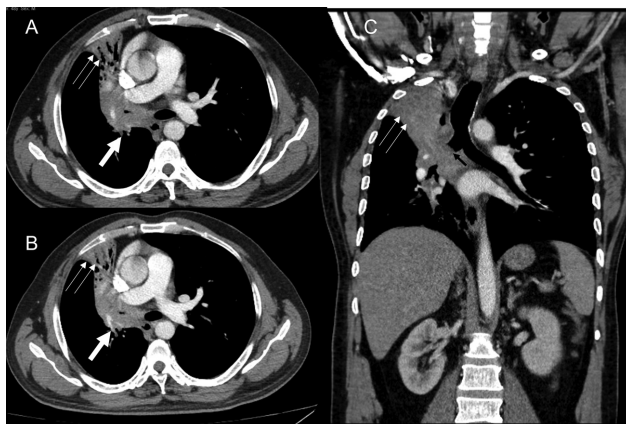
(A and B) Axial computed tomographic (CT) thorax sections demonstrate central hilar mass having convex margin (white arrow) causing occlusion of right upper lobe bronchus, bronchus intermedius, right middle lobe bronchus with the resultant collapse, with mild peripheral bronchiectasis of right upper and right middle lobe having retained secretions in the peripheral bronchi (double thin white arrow). The lesion infiltrates and merges with the ipsilateral mediastinal, hilar, and subcarinal nodes. (C) The coronal CT thorax section also reveals the medial extension into the right main bronchus (black arrow). No distant metastases. TNM stage: T4N2.
